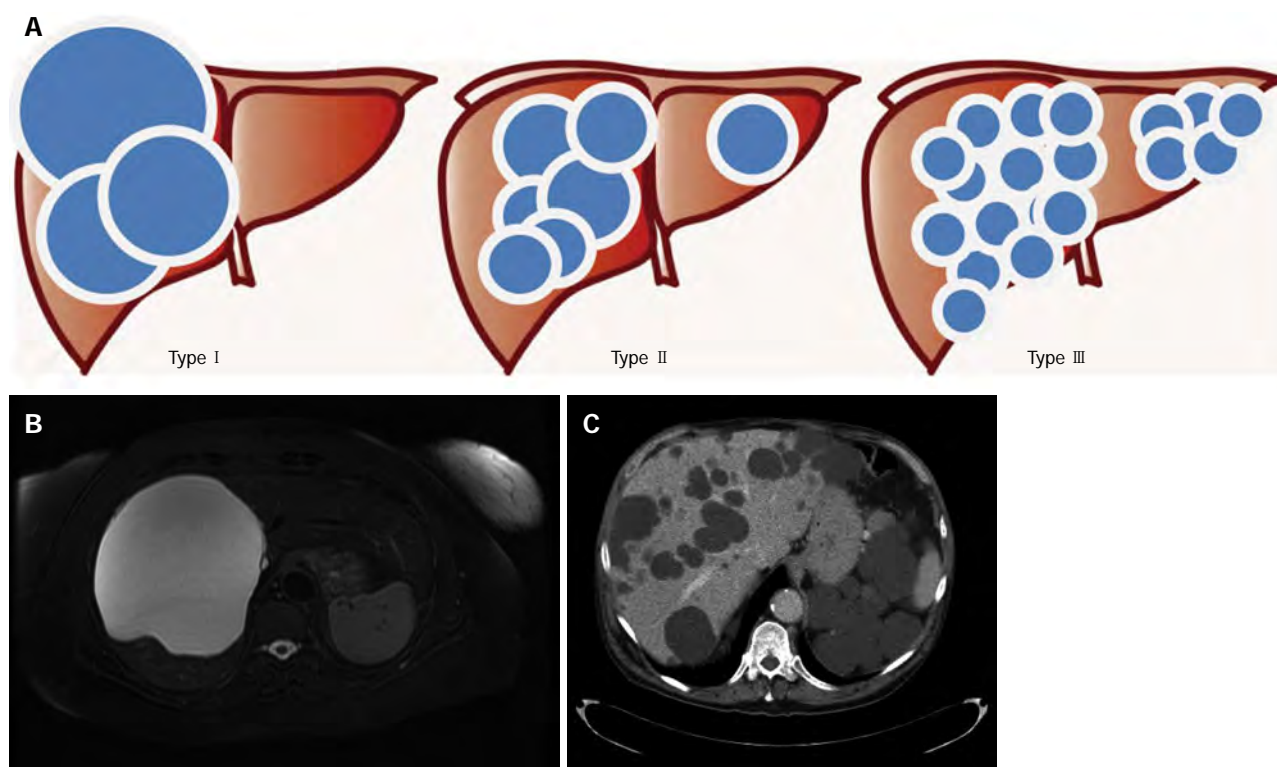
Gigot's classification for polycystic liver diseases. A: Graphical representation; B: Abdominal magnetic resonance imaging of a patient affected by Gigot I cystic liver disease; C: Abdominal computerized tomography of a patient affected by Gigot II cystic liver disease.
